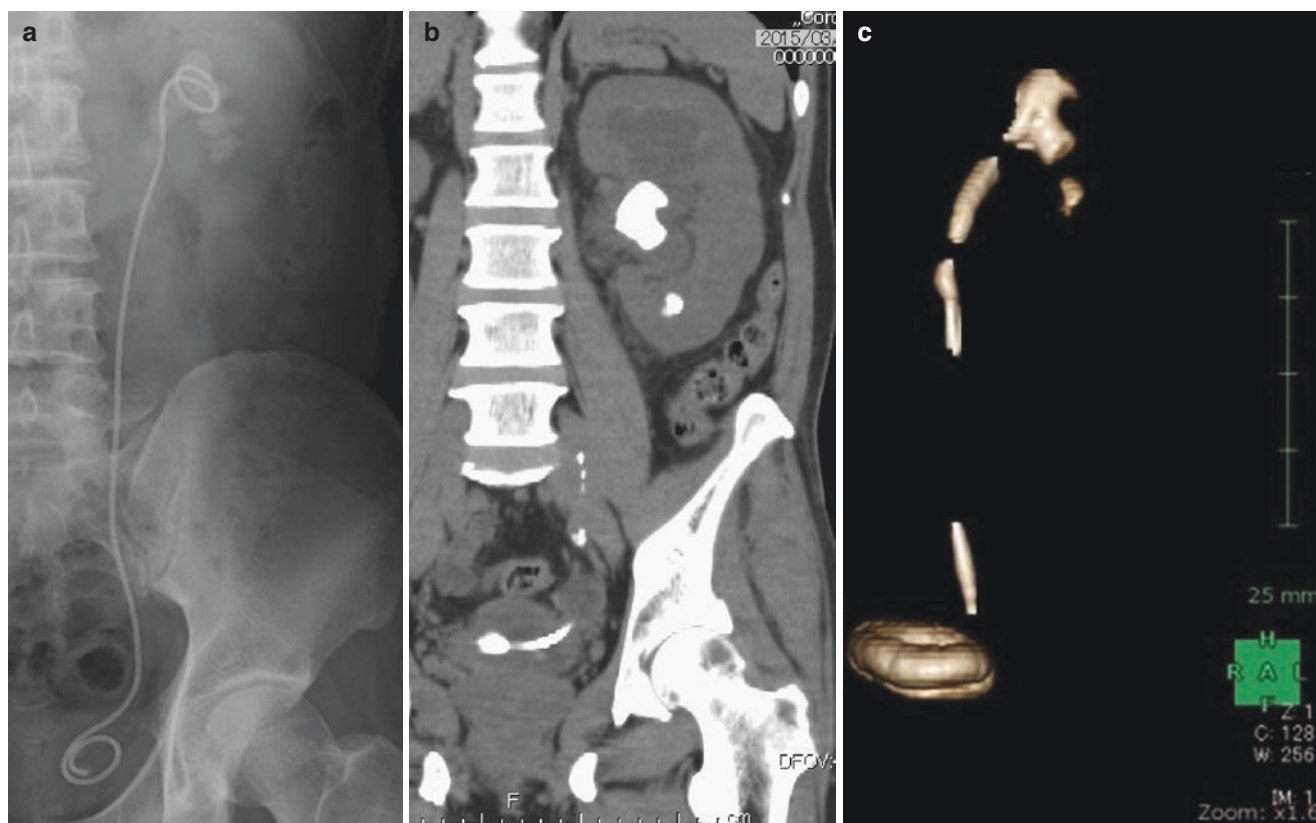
Images of ureteral stents with encrustation (a. KUB, b. CT, c. 3D-CT)
